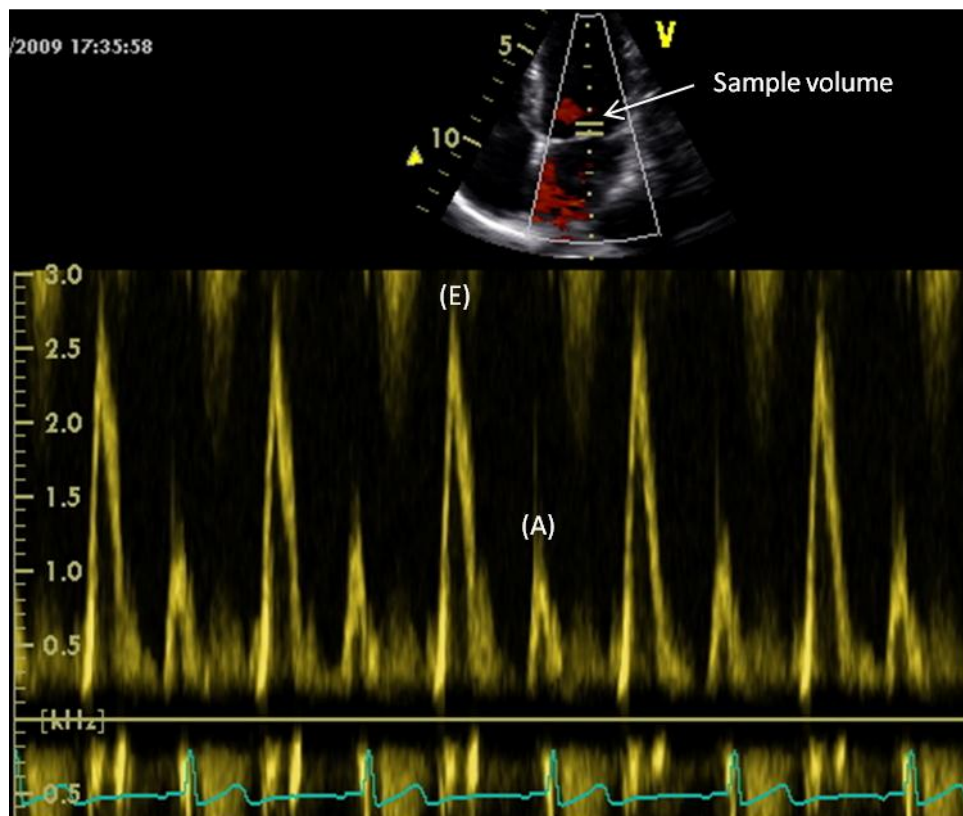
Example of an apical 4-chamber view and the measurement of mitral inflow velocities at rest.
